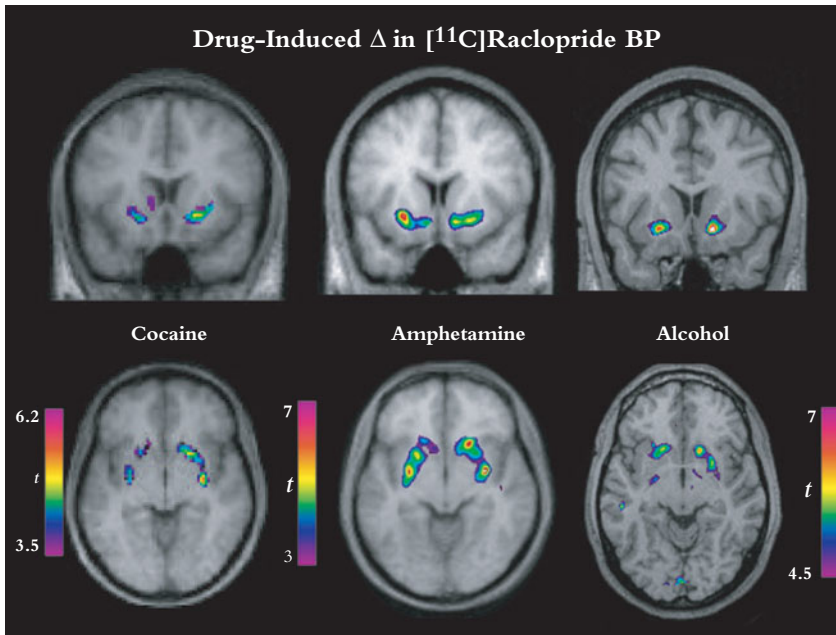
The figure depicts the ability of cocaine (left, 1.0mg/kg, taken intra-nasally), D-amphetamine (middle, 0.3 mg/kg, taken orally), and alcohol (right, 1 ml/kg, taken orally) to increase extracellular levels of dopamine in human striatum, as measured by positron emission tomography (PET) and changes in the binding of [^{11}C]raclopride. The colored images are t-maps, and they depict those regions where there were significant changes in tracer binding on the drug vs. placebo test session. The t-maps are superimposed on anatomical magnetic resonance images (MRI) from participants in the studies. Right side is on right. [Data are from Cox et al. (2009), Leyton et al. (2002, 2003) and Boileau et al. (2003).]
